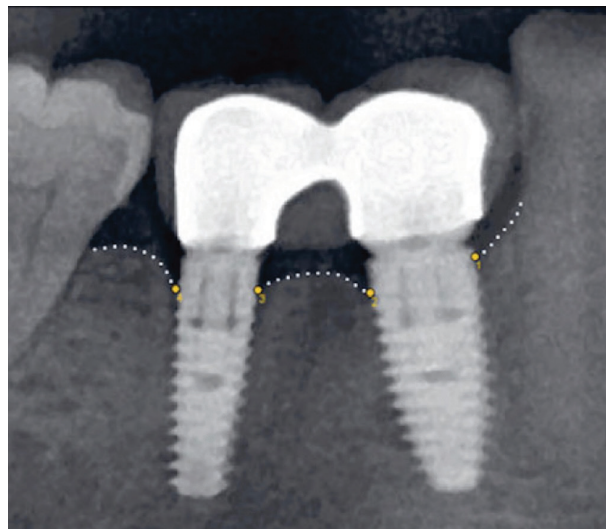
Panoramic radiographs were taken to monitor the progression of marginal bone loss
